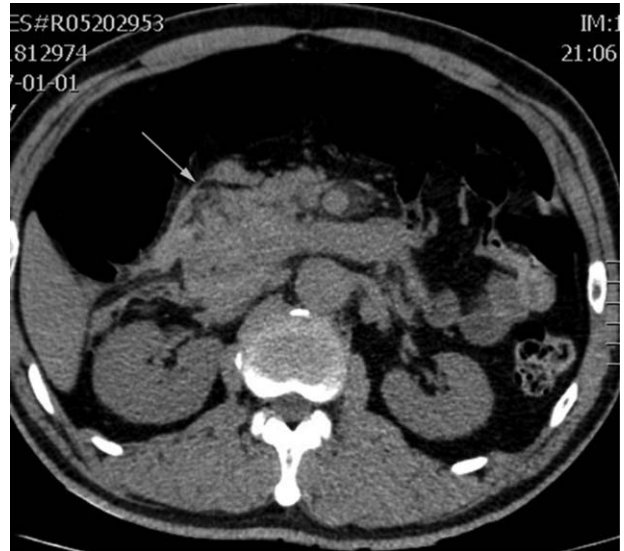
Noncontrast CT of the abdomen showed enlargement of pancreatic head and peripancreatic fat stranding. CT = computed tomography.
